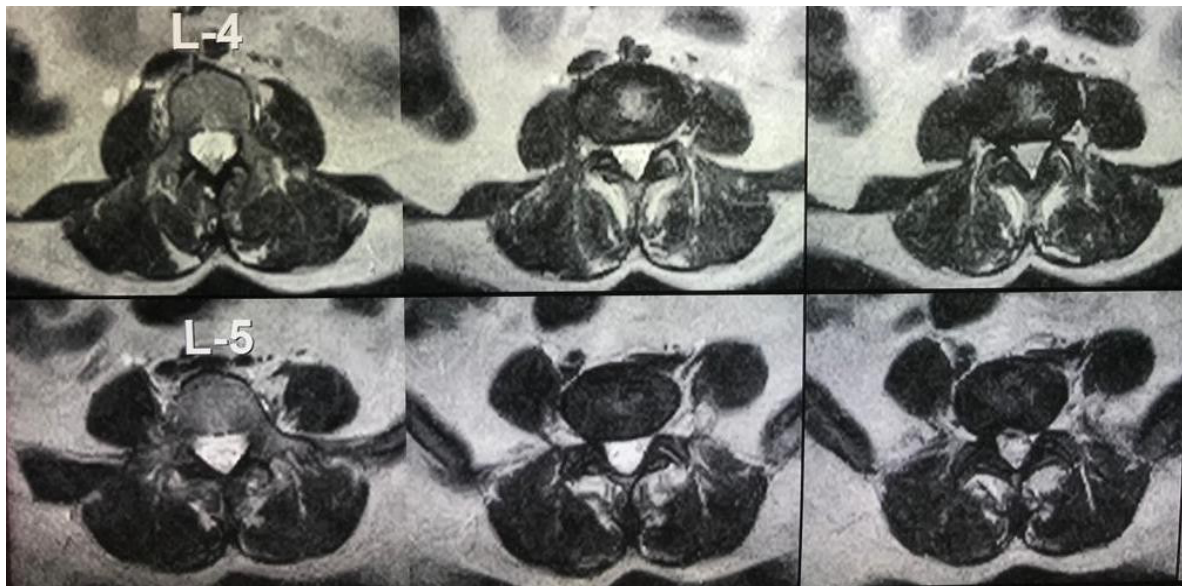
MRI Axial view of L4-L5 shows disc protrusion (MSU grade 1-B)
